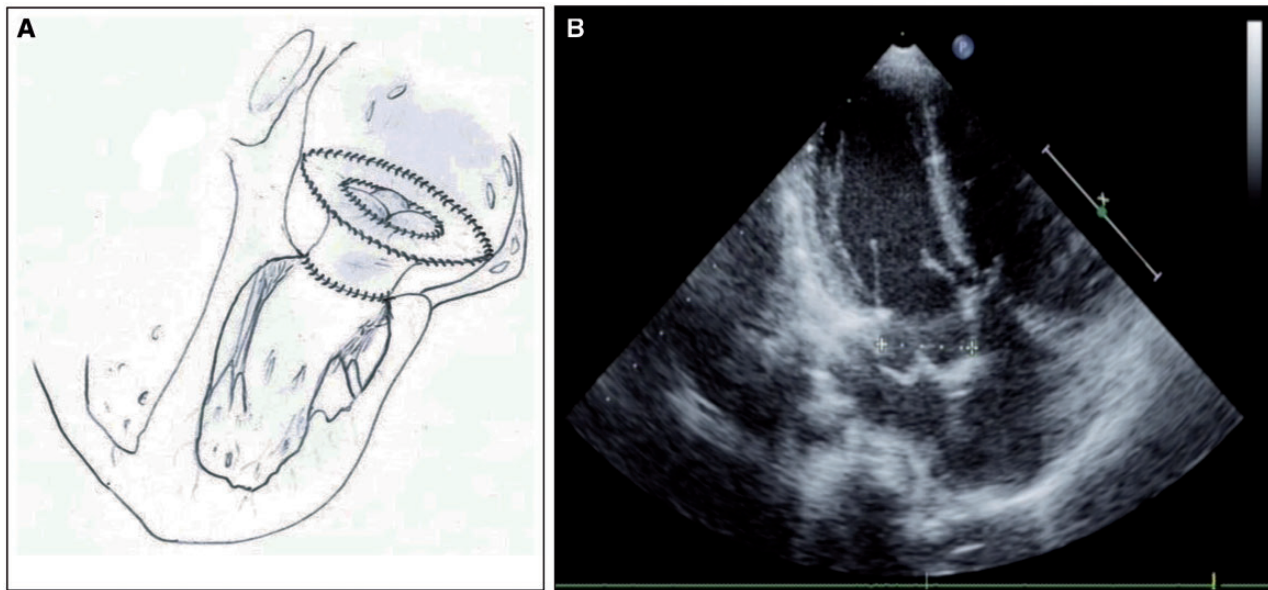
Echocardiographic follow-up after the Ross II procedure.
